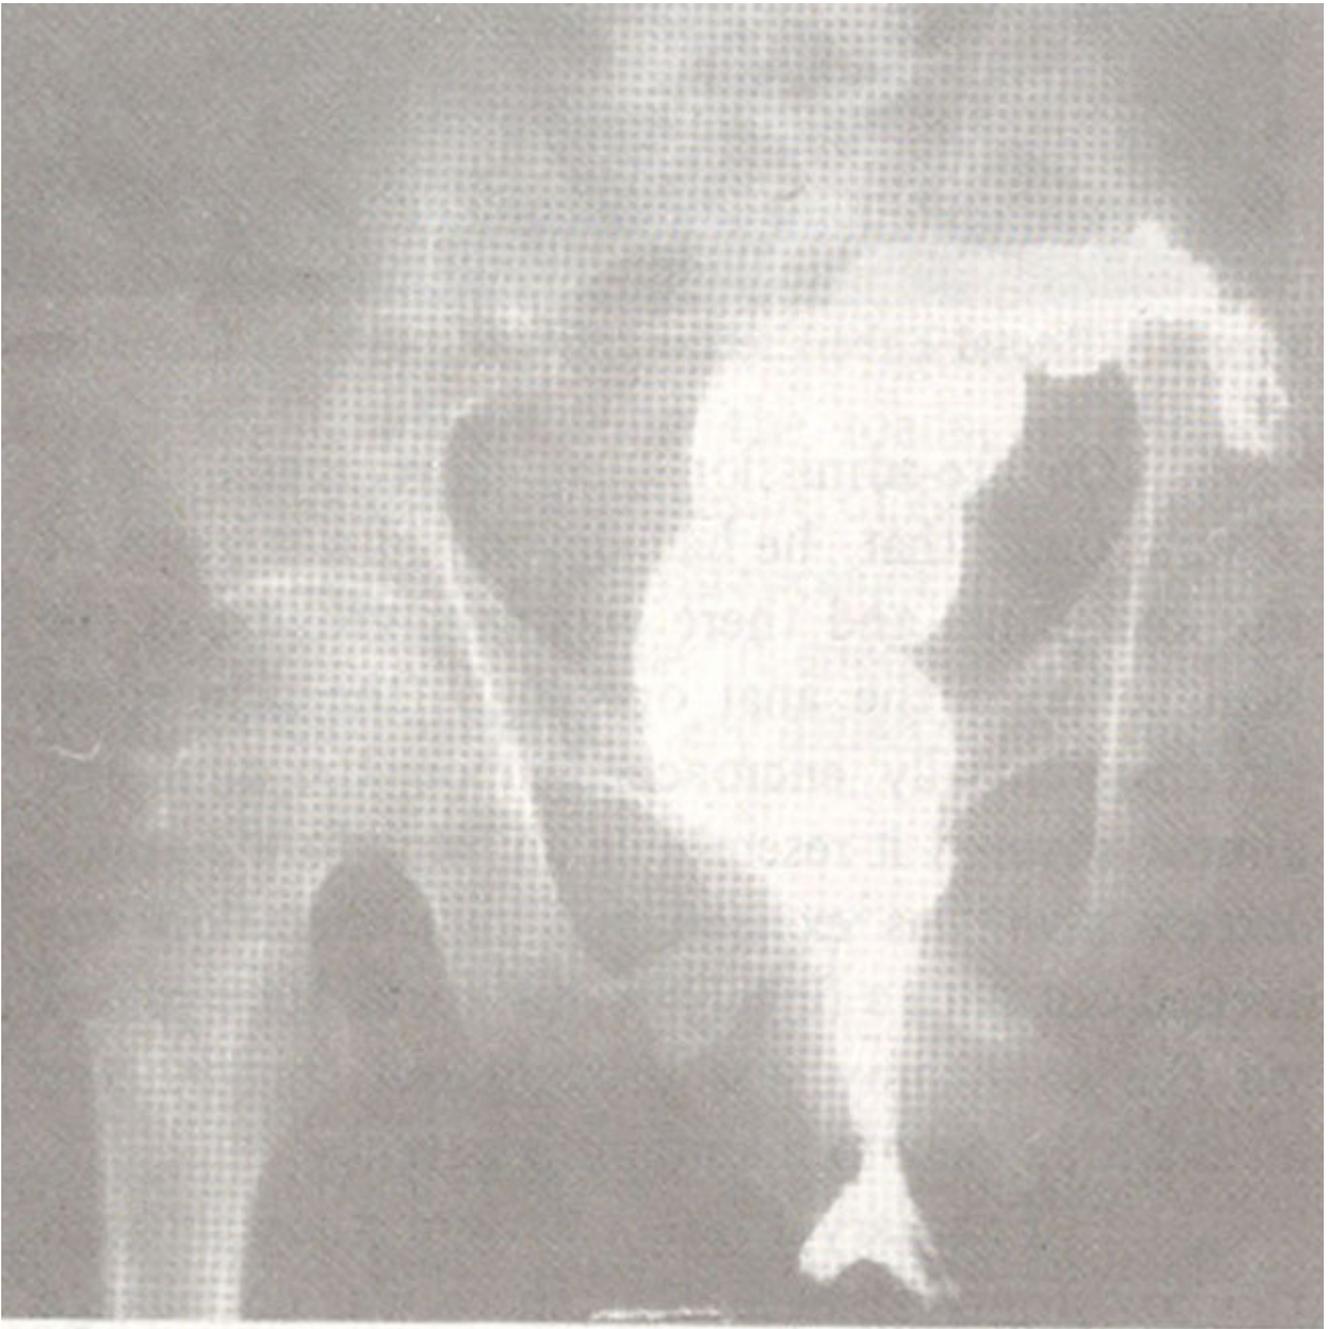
Barium X-ray after the Splint. Showing healing of Rectum & Anal Canal around the Splint.
